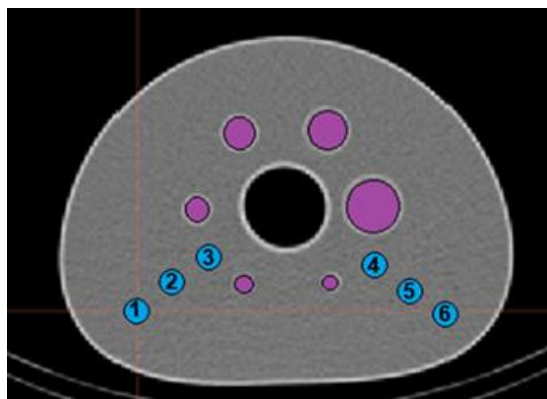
The CT image shown the areas where we marked the ROI to determine the number of average counts in spheres (red) and background (blue) on SPECT/CT.
